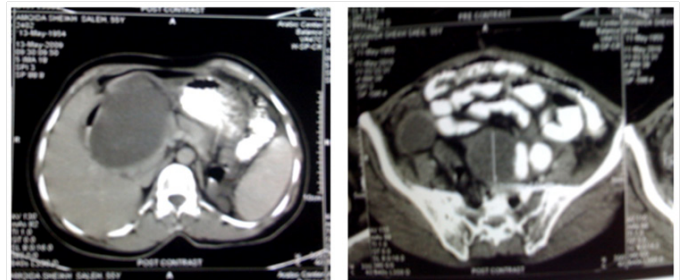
Abdominal CT scan shows collection fluid.
